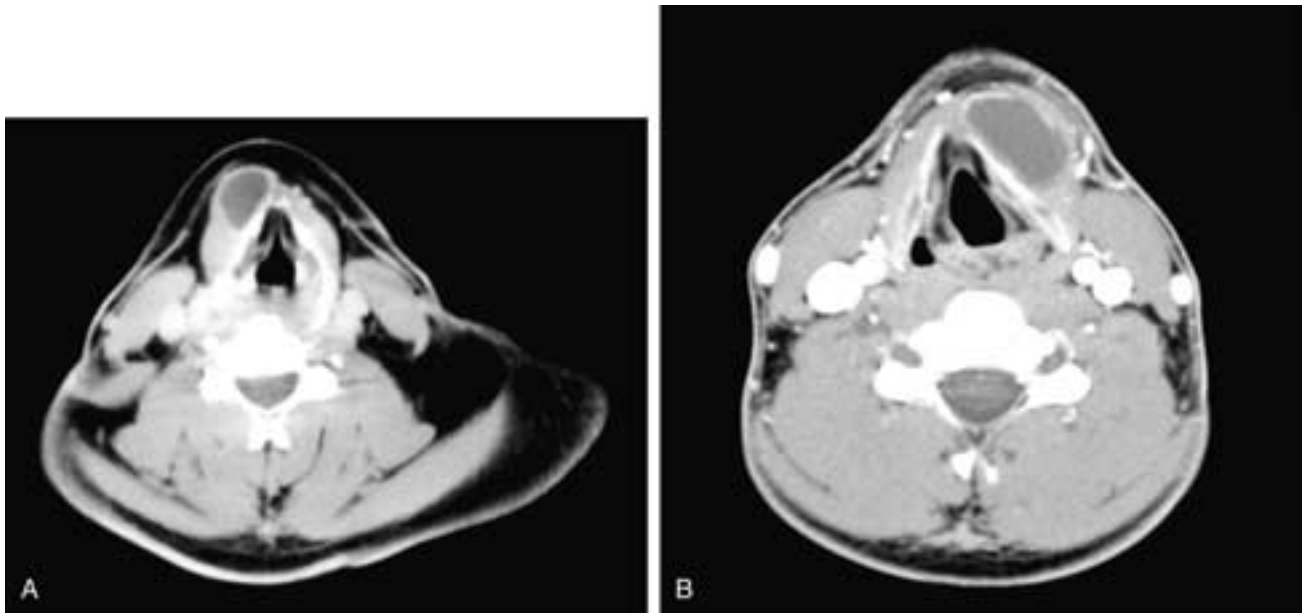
Axial contrast-enhanced CT scans on two different patients. In A, there is a smooth-walled cyst in the right neck, adjacent to the outer aspect of the thyroid cartilage and deep to the strap muscle. In B, a slightly larger but similar cyst is present on the left side. These were both thyroglossal duct cysts.
